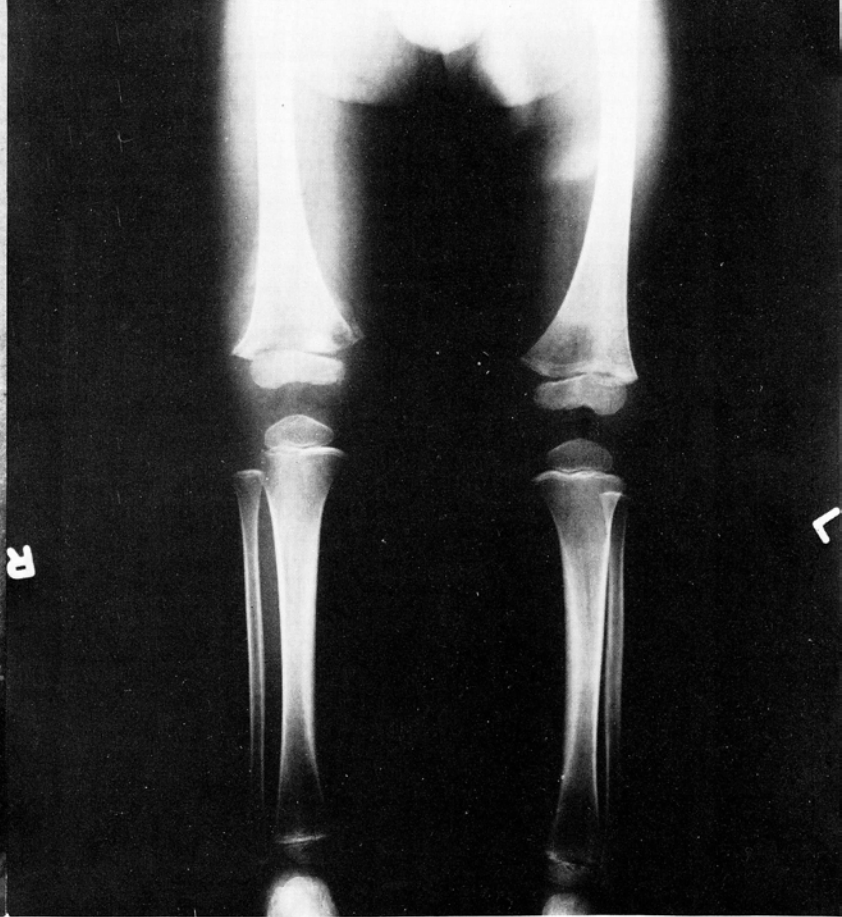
Roentgenogram showing no large soft tissue mass.
